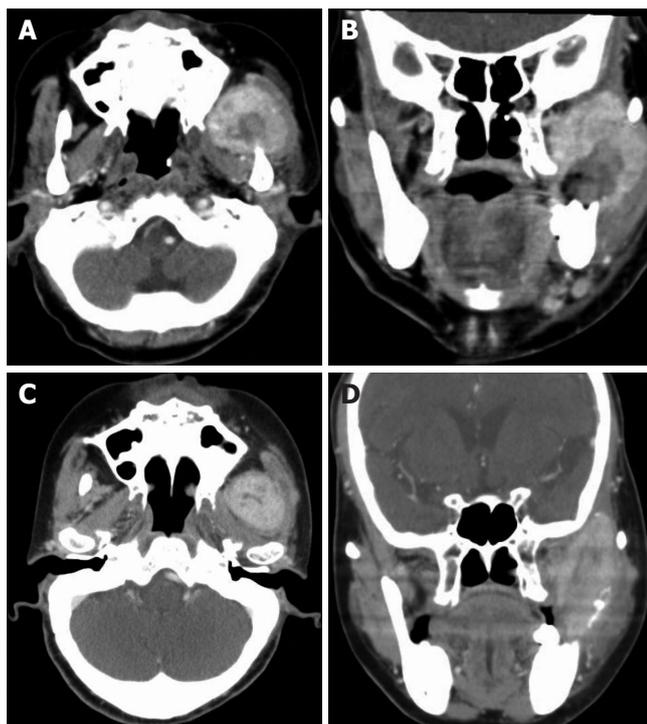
Axial and coronal CT scan of the neck with intravenous contrast showing a 6.2 cm x 5.0 cm, heterogeneously enhancing mass, which appears to be a left parapharyngeal mass involving the pterygoid muscle and temporal muscle (A and B); axial and coronal CT scan of the head and neck showing a 4.0 cm x 2.5 cm mass which shrunk after completion of radiotherapy (C and D).
